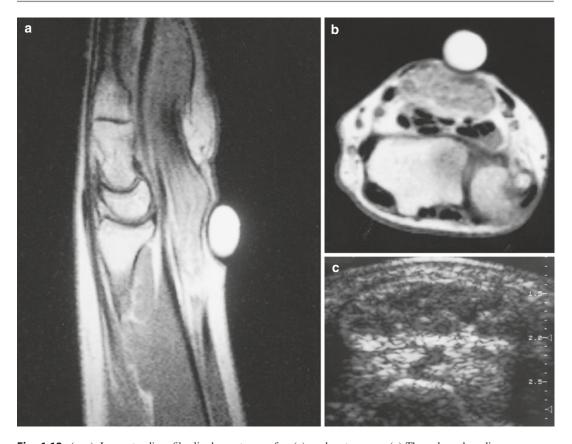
(a–c) Long-standing fibrolipohamartoma of median nerve (MN) in a 54-year-old woman. (a) Sagittal spin-echo T1-weighted MR image of the wrist. (b) Axial SE T1-weighted MR image proximal to the carpal tunnel. (c) Transverse US image of carpal tunnel. Enlargement of the median nerve in the distal forearm (b), carpal tunnel
